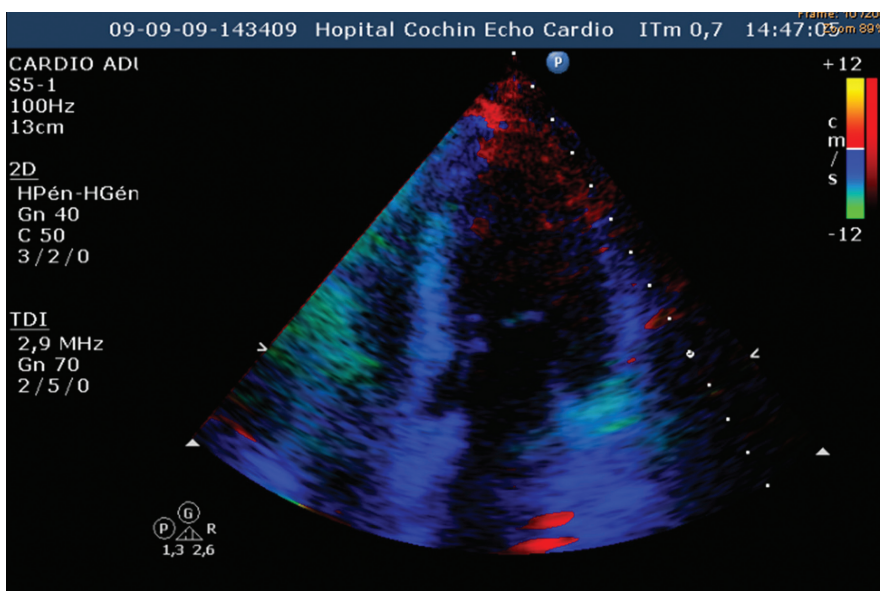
Echocardiography, strain imaging of the left ventricle, 4 chamber apical view. Colours are related to myocardial velocities.
